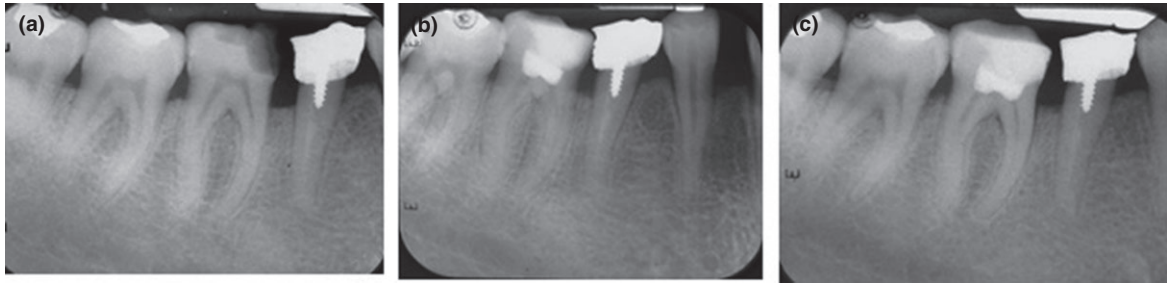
Radiographs of 30-year-old female patient with signs and symptoms clinically suggestive of irreversible pulpitis and normal periapex in tooth 46. (a) preoperative radiograph, (b) Immediate postoperative radiograph, (c) 3-year recall showing normal periapex.
